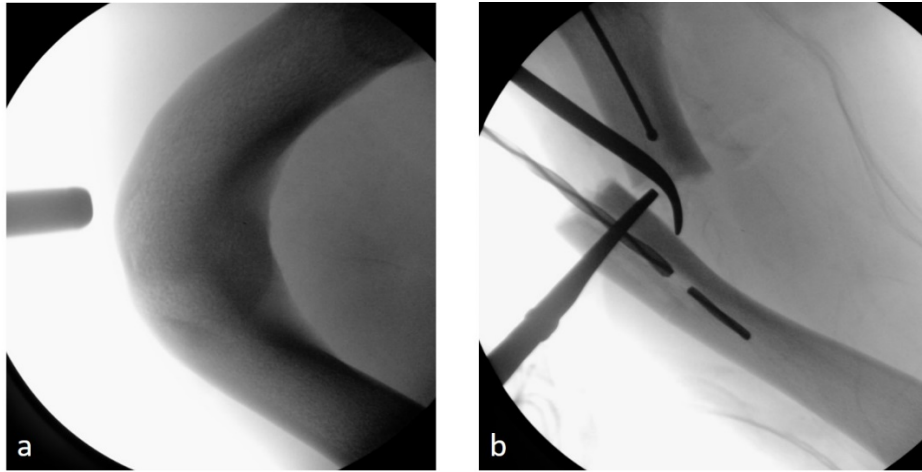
Intraoperative X-rays of the right femur: a) Initial condition of deformity; b) Breakage of the drill bit.
